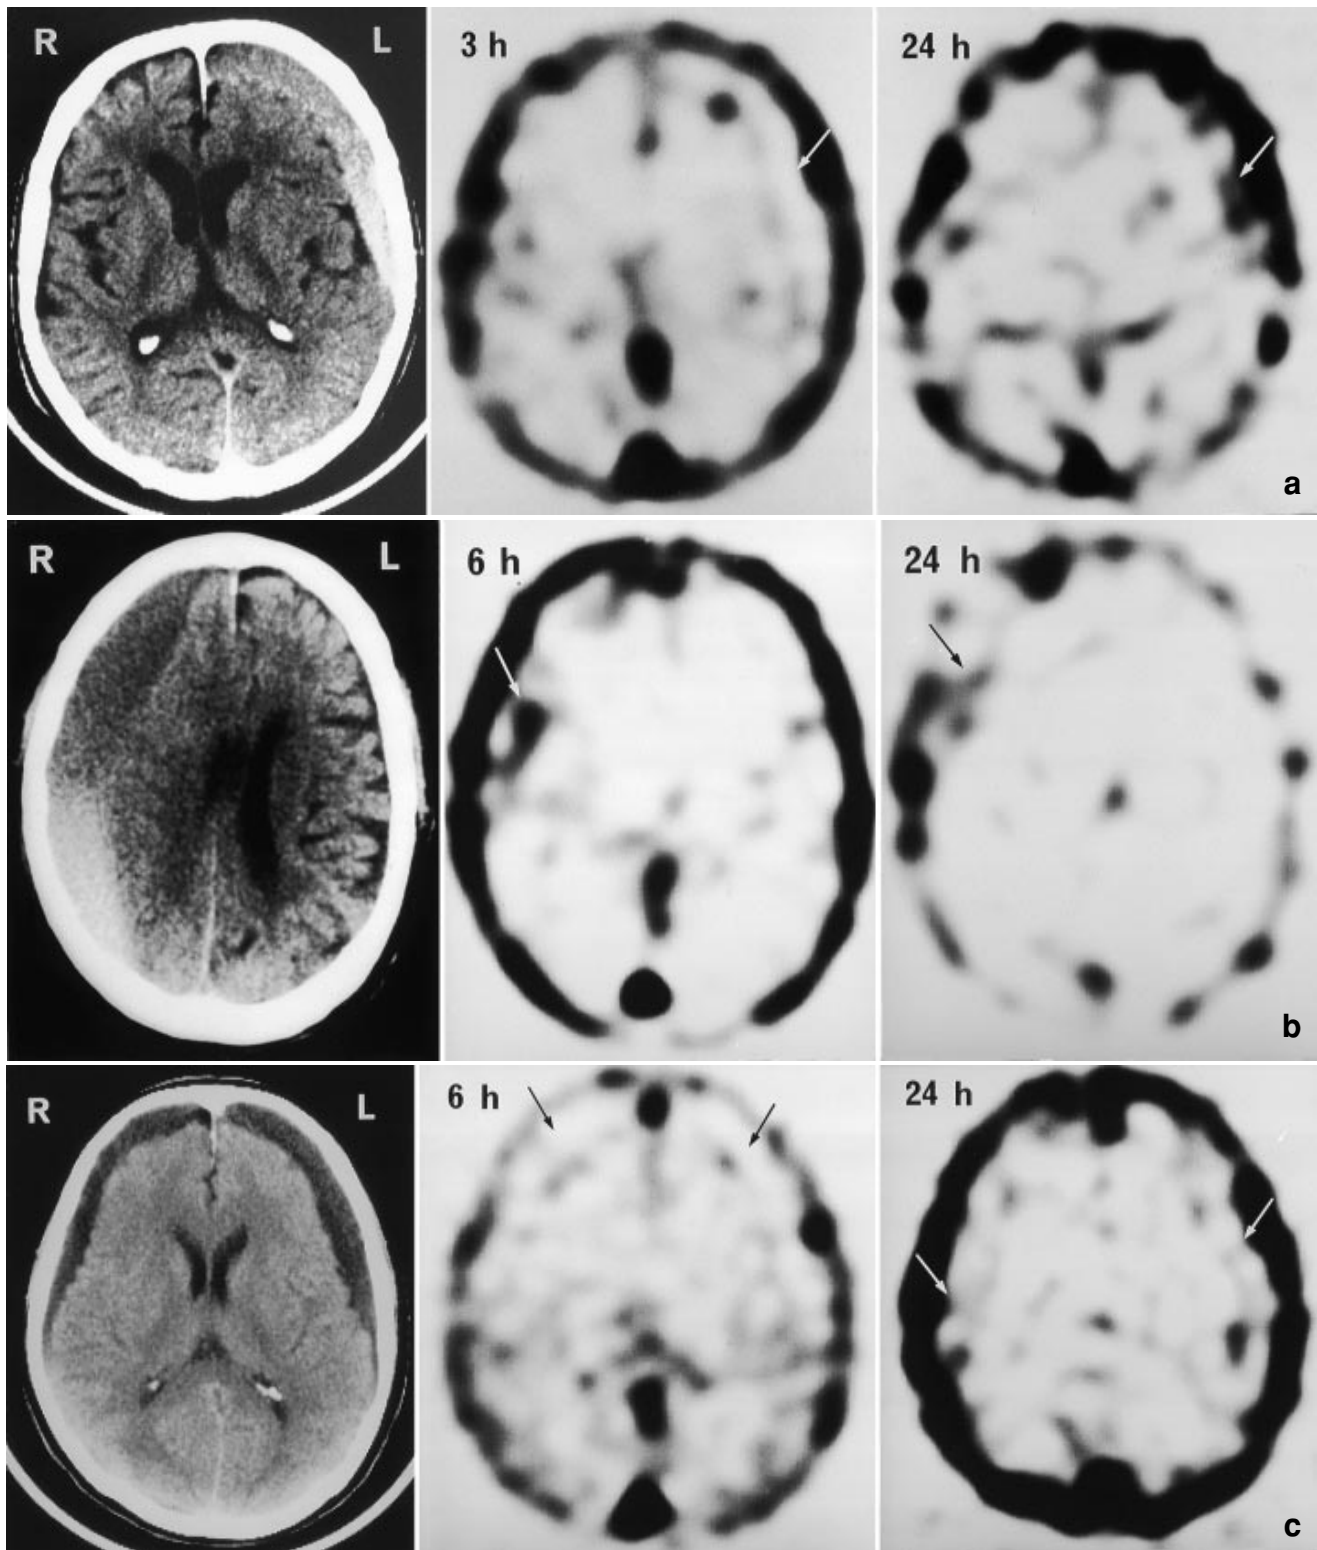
Left: CT; Center: Scintigram 3 or 6 h after intravenous [^{99m}Tc]-HSA injection; Right: Scintigram 24 h after intravenous [^{99m}Tc]-HSA injection. (a) Case 1; 64-year-old man. Accumulation of ^{99m}Tc -HSA in the haematoma cavity was not evident 3 h after isotope injection, but was seen at 24 h (arrows). (b) Case 2; 85-year-old man (c) Case 4: 73-year-old man with bilateral subdural effusion. Accumulation of ^{99m}Tc -HSA in the haematoma cavities is indicated by arrows
